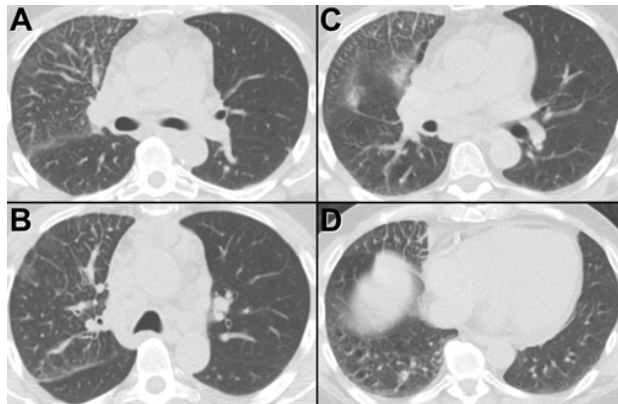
Representative axial thoracic CT displayed in lung windows performed 3 months prior to CT obtained at presentation.
